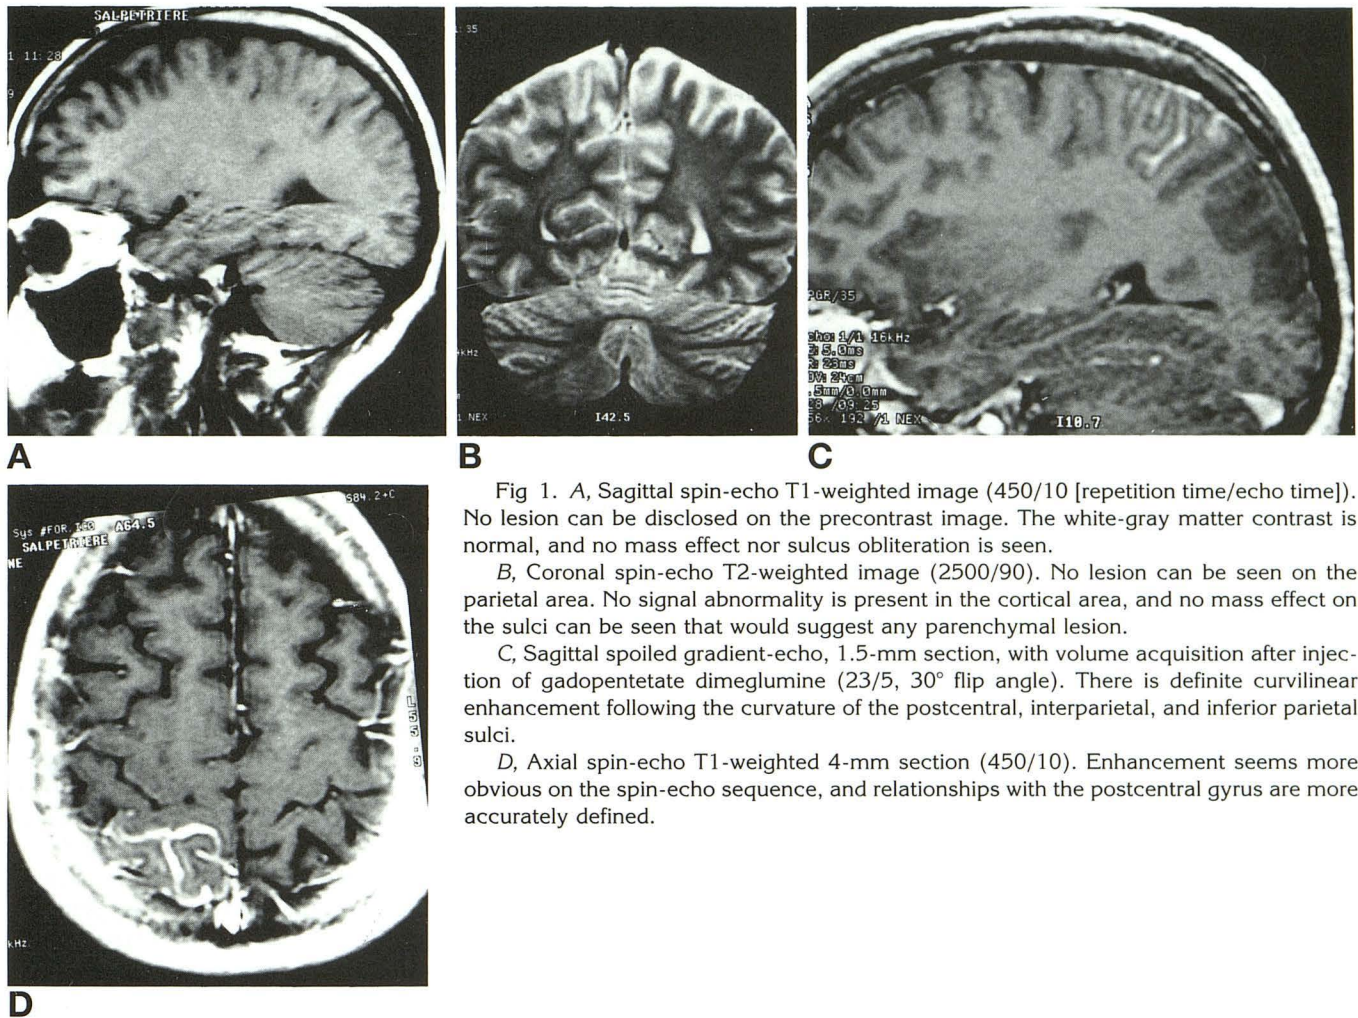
A, Sagittal spin-echo T1-weighted image (450/10 [repetition time/echo time]). No lesion can be disclosed on the precontrast image. The white-gray matter contrast is normal, and no mass effect nor sulcus obliteration is seen.
